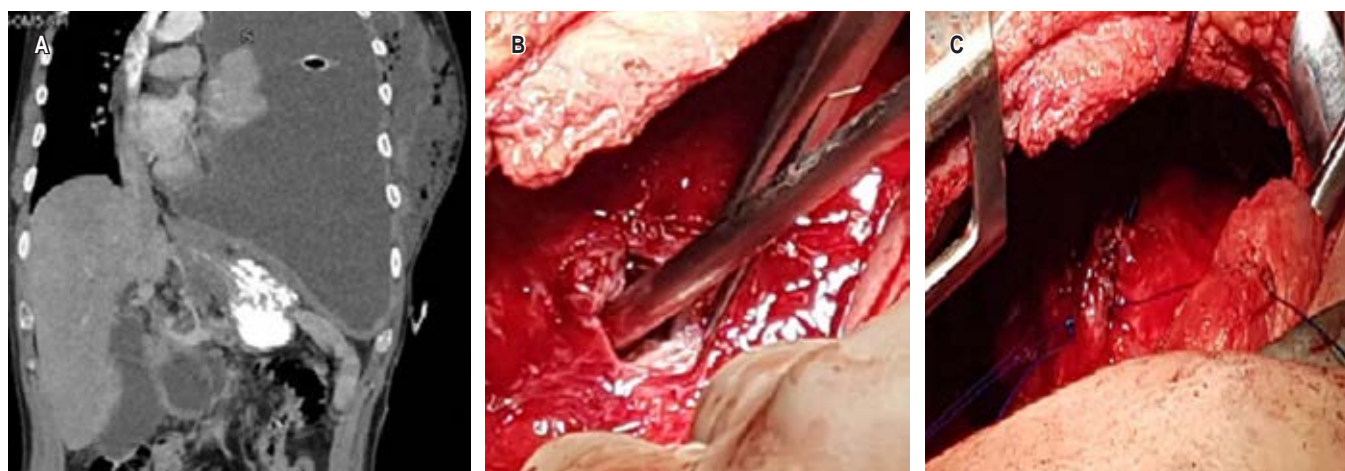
A) CT scan of case 1; shows left pleural effusion. B) Fistula site in diaphragm. C) Closure of defect with nonabsorbable suture.
